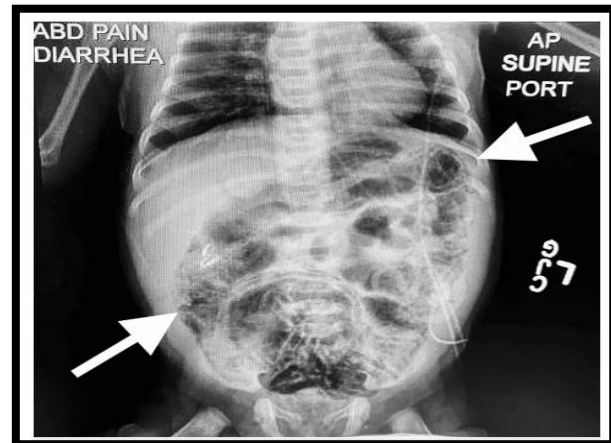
Abdominal x-ray showing dilated loops of bowel and pneumatosis
